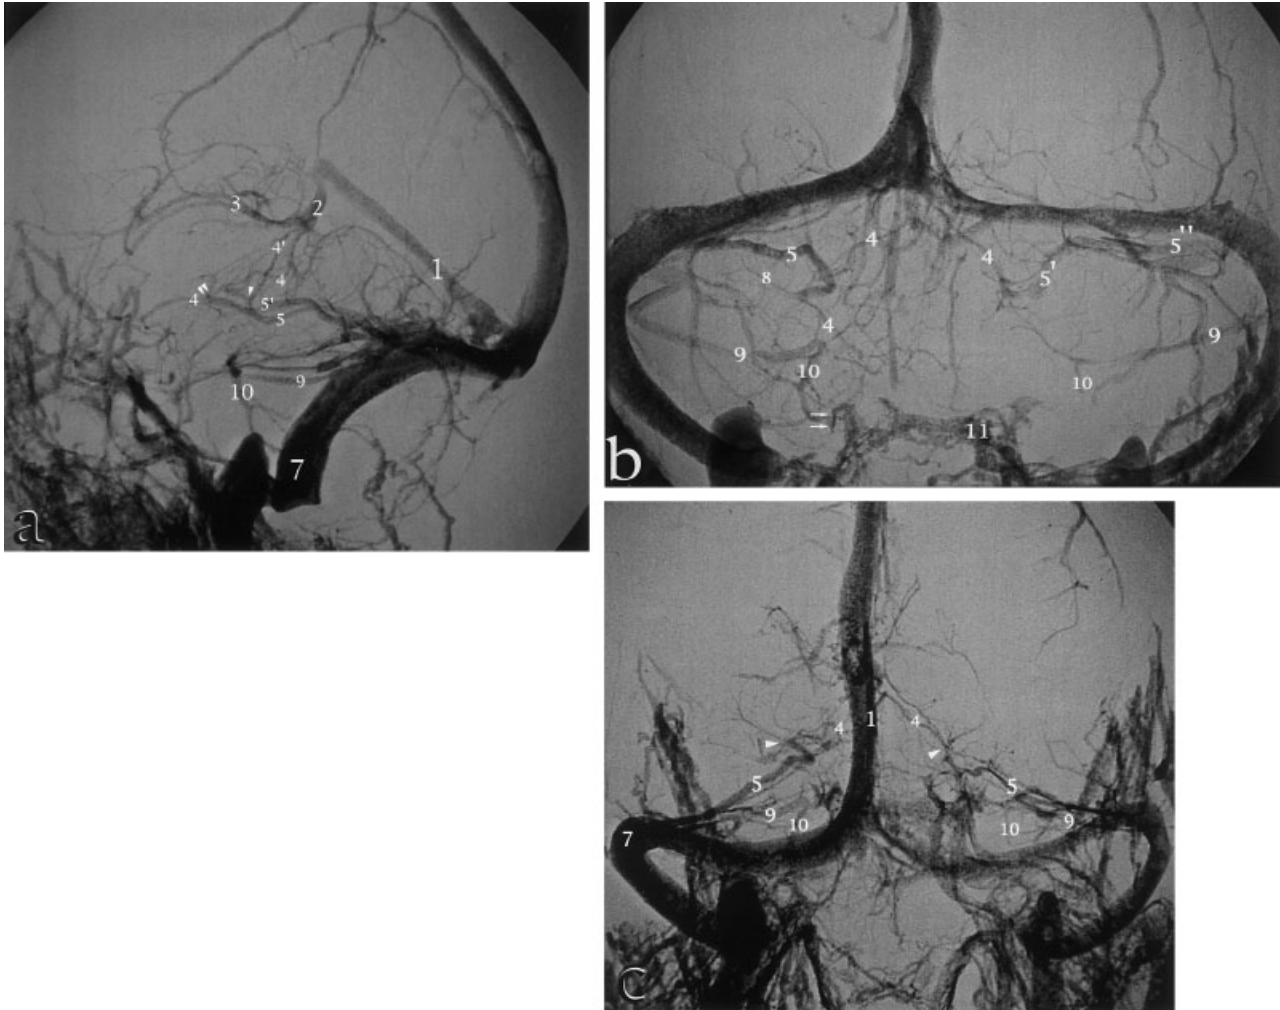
Plain X-ray of the corrosion cast depicting the angiographic anatomy of the bilateral tentorial sinus drainage of the BV. a: Lateral view. The tentorial sinuses draining both BVs (4 and 4', right and left, respectively) are seen on both sides. Both tentorial venous sinuses (5 and 5', right and left, respectively) are seen to terminate on the middle third of the transverse sinus. The arrowhead points to the junction between left BV and left tentorial venous sinus. The double arrowhead points at the junction between right BV and right tentorial venous sinus. b: Anteroposterior view. Note that the left tentorial venous sinus (5') that drains the BV seems to enter a larger tentorial sinus (5''). On the corrosion cast, there were two distinct tentorial
